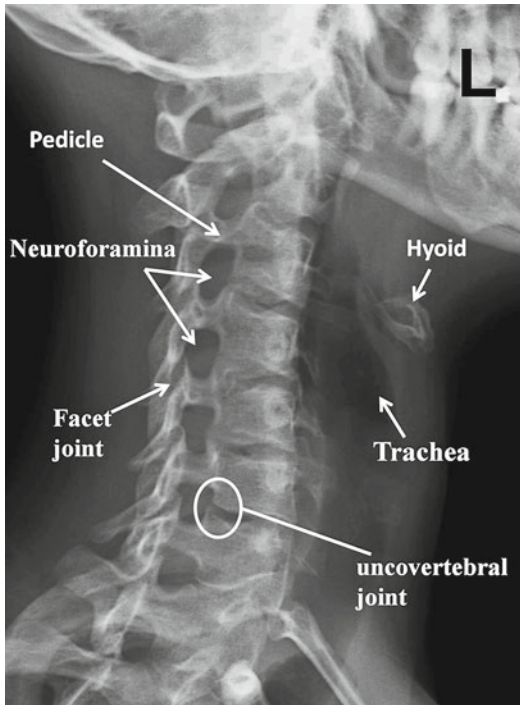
Radiographic anatomy of an oblique projection of the cervical spine. Note that the right neural foramen is profiled as the mandible is turned toward the patient's left (L)
